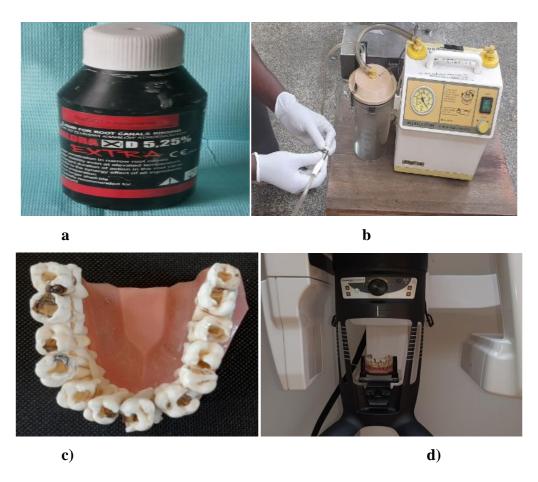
Image of NaOCl (a), Suction machine (b) teeth mounted on the model(c) using beading wax (India), and loaded on the CBCT scanner (d) (Sirona, Germany) for scanning
